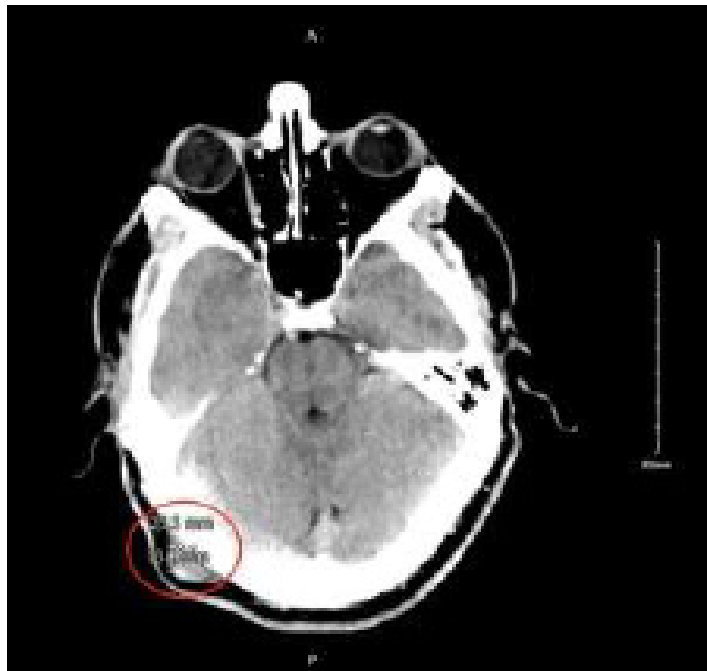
Axial computed tomography of the head without contrast demonstrating a focal, soft-tissue lesion abutting the intact calvarium, measuring 2.0 x 1.3 centimeters that was isodense to the surrounding muscle (red oval).
